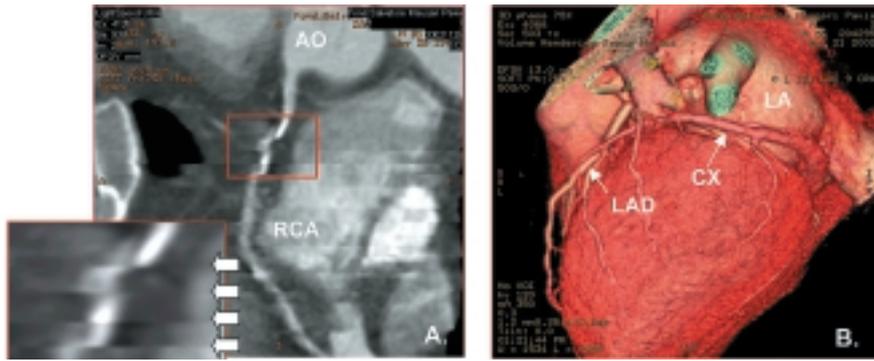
Technical artifacts in multislice spiral computed tomographic coronary imaging. A: evident artifacts due to the breathing motion during acquisition produce, in an image reconstructed with maximum intensity projection, a series of gradations (arrows) which prevent a satisfactory assessment of the right coronary artery (RCA). B: this volume-rendered three-dimensional image does not allow an adequate visualization of the left anterior descending artery (LAD) and circumflex coronary artery (CX) due to the masking effect of the venous network. AO = ascending aorta; LA = left atrium.
